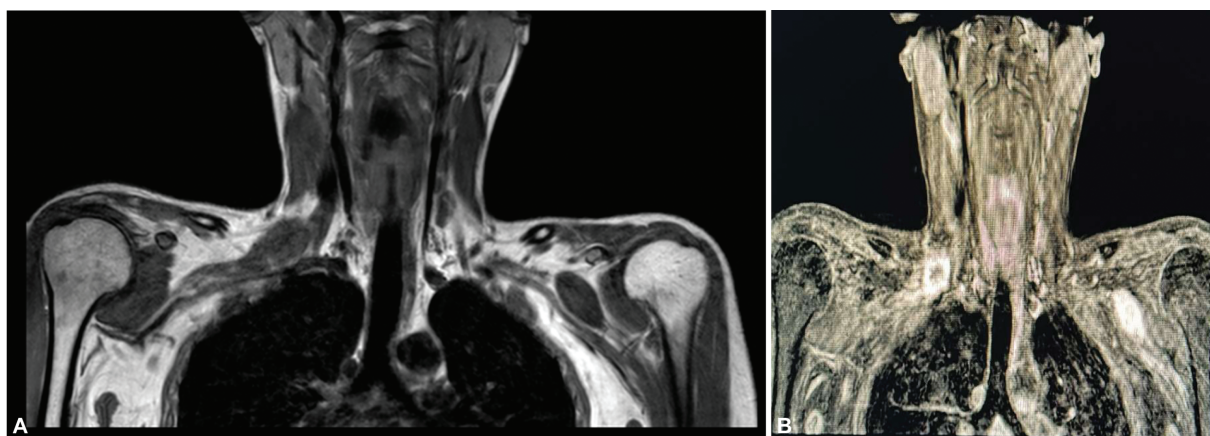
(A) Shows dumb-bell shaped tumors along the trunks of brachial plexuses bilaterally. Lesions are T1 homogeneously hypointense. (B) shows homogenous contrast enhancement of both the lesions on CE MRI.
